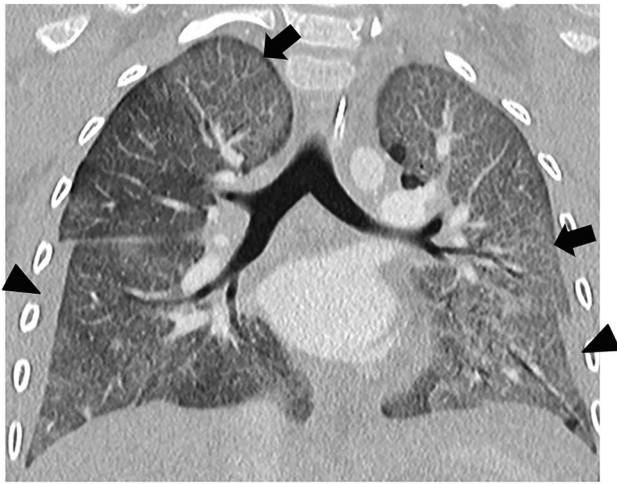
Pneumocystis jirovecii* pneumonia in a 6-year-old male with acute lymphocytic leukemia (ALL) on week 14 of therapy with prolonged febrile neutropenia and respiratory distress requiring intensive care admission. He was diagnosed with *Pneumocystis jirovecii* pneumonia by bronchoalveolar lavage (BAL). Coronal CT image shows diffuse ground glass opacification (arrows). Small pleural effusions are present (arrowheads), which are atypical in PCP
